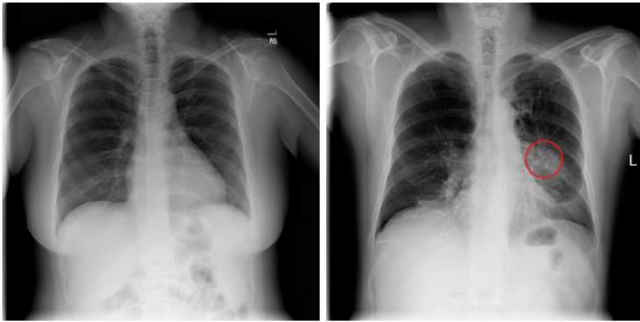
An example of a radiograph without pathology (left) and with pathology (right), highlighted by a red circle from the selected data set
